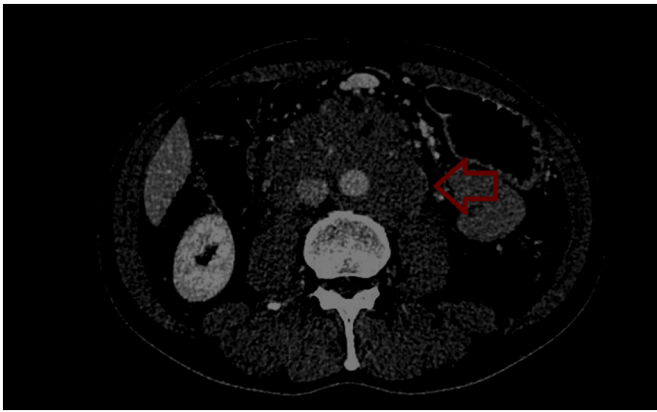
Malignant retroperitoneal lymphadenopathy at CT scan.
